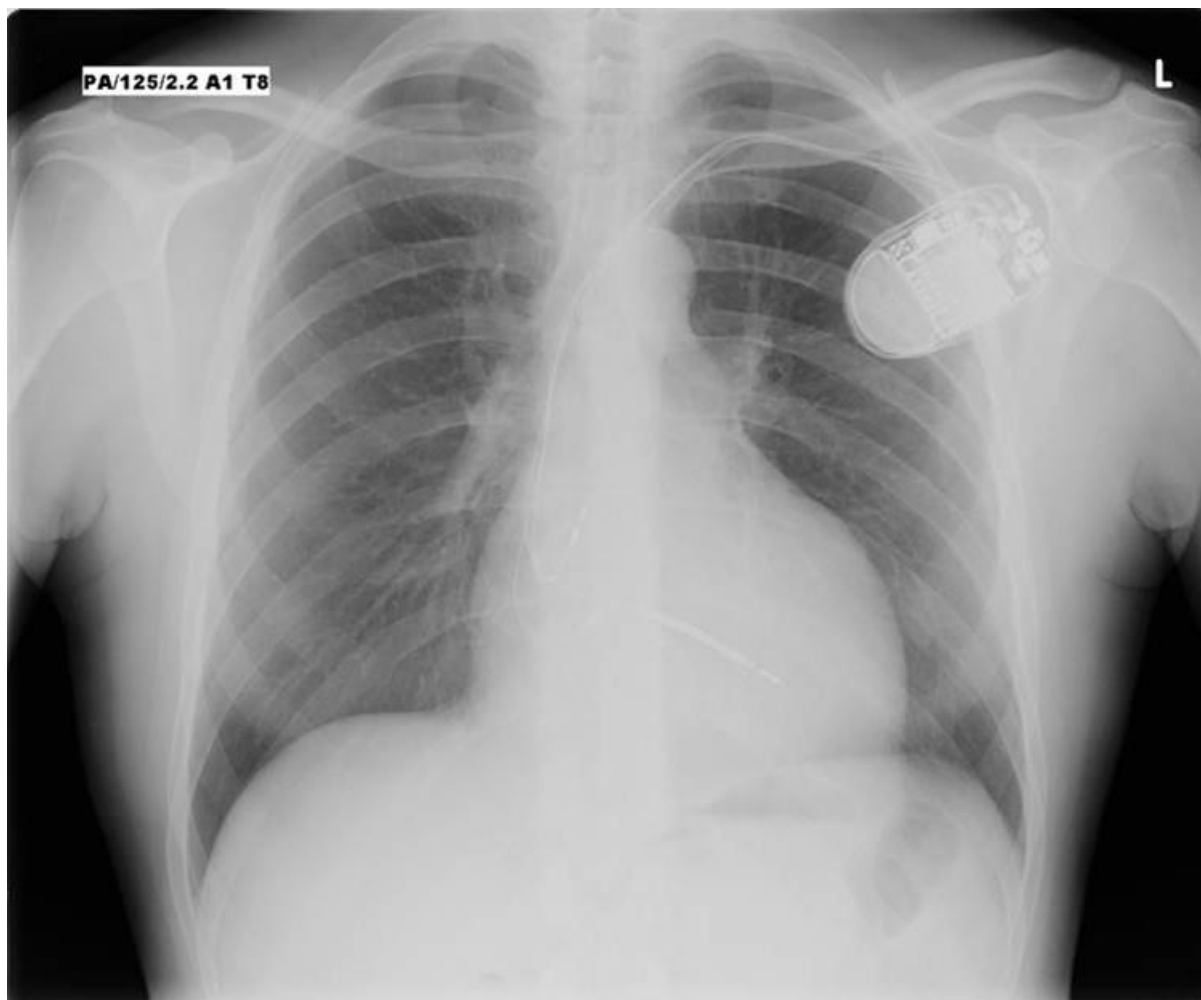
Chest X-ray in posteroanterior (PA) projection. Visible implanted CRT-D and cardiomegaly.
